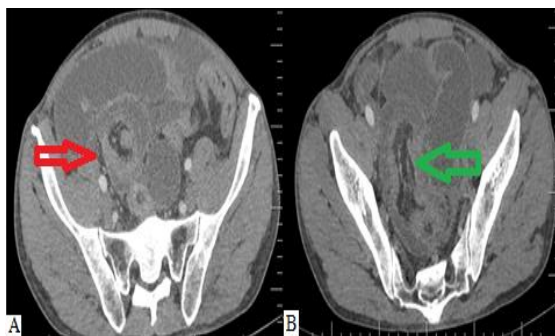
Computed tomography showing: A. "On target" signal (red arrow); B. Small bowel loop intussusception (green arrow).
